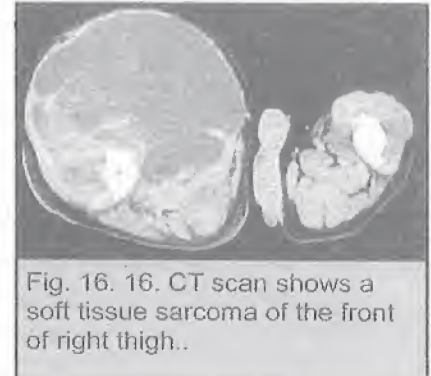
16. CT scan shows a soft tissue sarcoma of the front of right thigh..
